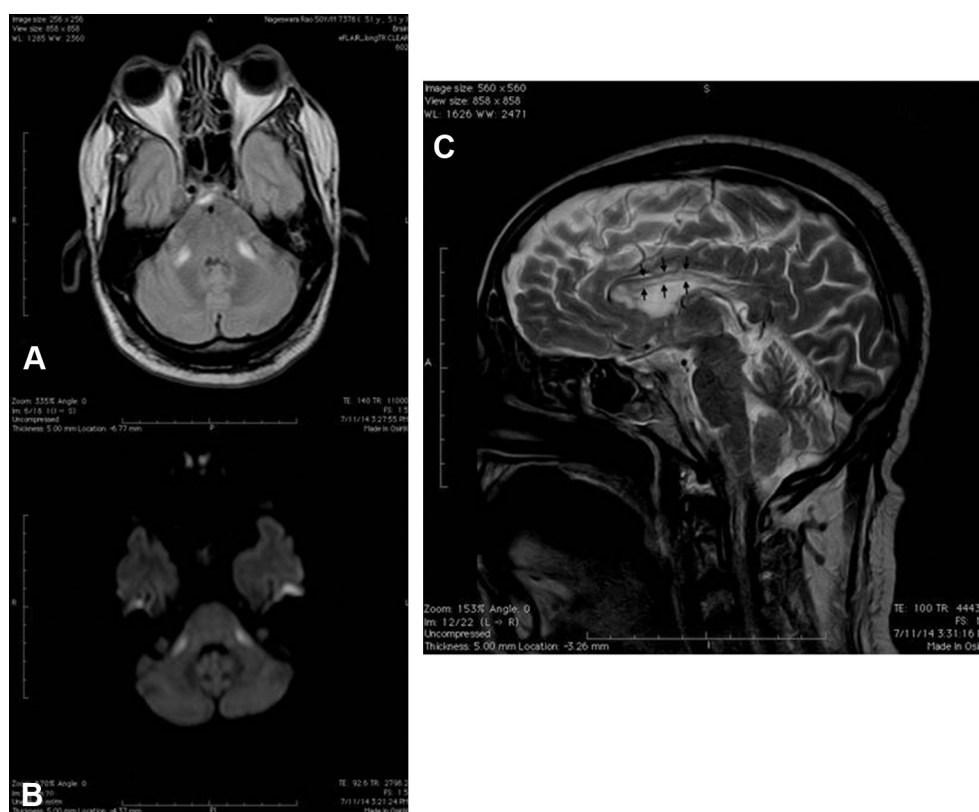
A–B: MRI brain axial flair images and DWI showing bilateral symmetric hyper intensities and restricted diffusion in bilateral middle cerebellar peduncles. C: MRI brain sagittal T2WI shows hyper intensity in the middle fibres of corpus callosum (arrows) with relative sparing of dorsal and ventral fibres showing the classic “Sandwich sign”.
